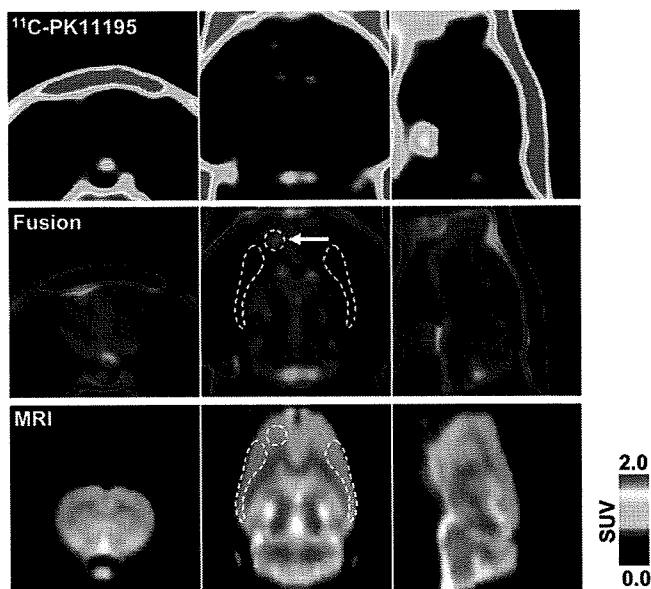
Representative ^{11}C -PK11195 PET image coregistered with MRI template 8 d after generation of unilateral (left hemisphere) cortical spreading depression. PET image was reconstructed with MAP algorithm and summed from 5 to 60 min after radioligand injection. Arrow in middle panel indicates KCl-microinjected area (core). White broken lines in middle and bottom panels indicate ROIs (core, ipsilateral, and contralateral, respectively) defined in this study.
